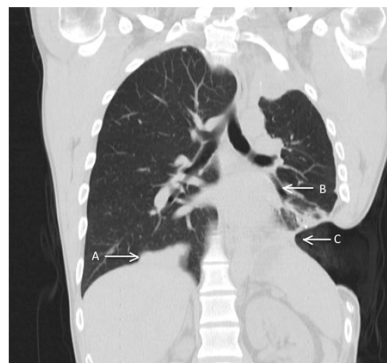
Preoperative computed tomography scan assessment of the thorax-case1. Coronal plane showing (A) metastatic implants in the right hemithorax, (B) fistula and (C) left thoracostomy.
